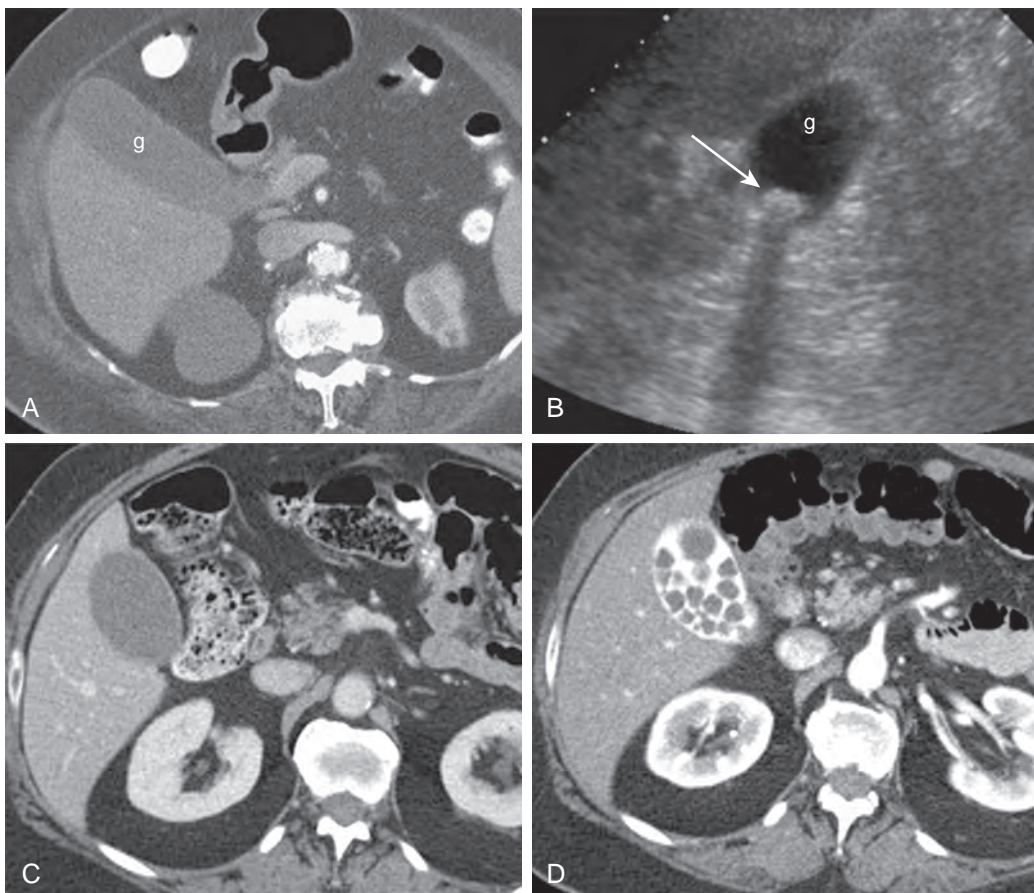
Noncalcified gallstones not visualized at CT. A. CT scan demonstrates no stones in the gallbladder (g). B. Ultrasound performed immediately after CT demonstrates shadowing stone (arrow) in gallbladder (g) lumen. C. CT scan in a different patient demonstrates no stones in the gallbladder. D. CT performed several days later in the same patient now demonstrates multiple stones in the gallbladder because of vicarious excretion of previously administered intravenous contrast material in the gallbladder.
